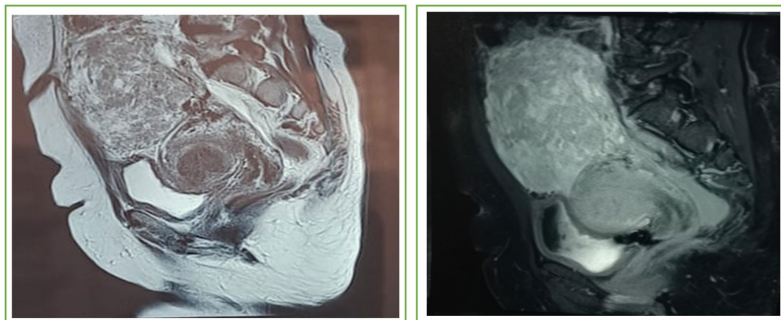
Pelvic MRI—T2-weighted sagittal section.
